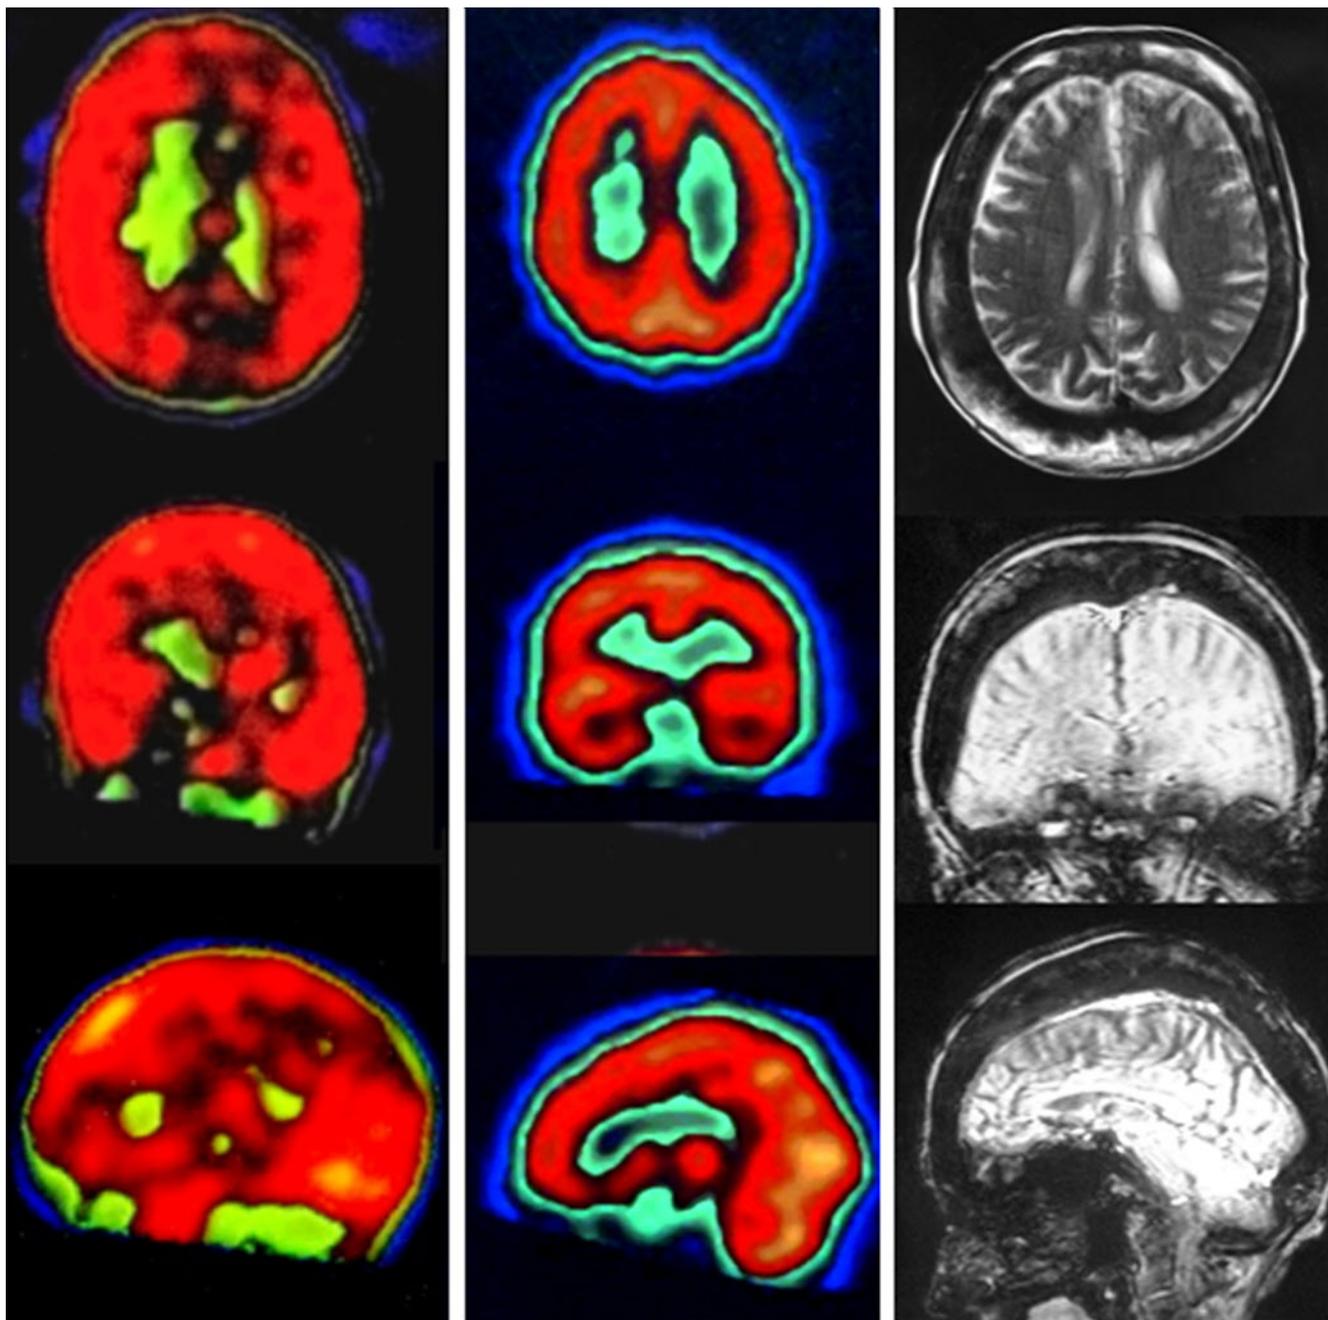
(Left) ^{99m}Tc -HMPAO brain SPECT scan transaxial (top), coronal (middle) and sagittal (bottom) images showing apparent marked thickening of the grey matter
